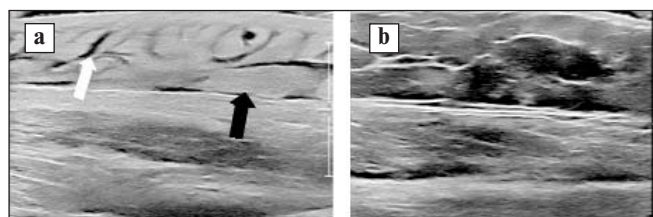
Ultrasound of soft tissues: a – diffuse increase in the echogenicity of the subcutaneous fat (black arrow) with its thinning compared with the contralateral side, thickened anechogenic partitions – septa (white arrow) – between fat lobules; b – contralateral side (normal fat, B-mode)
